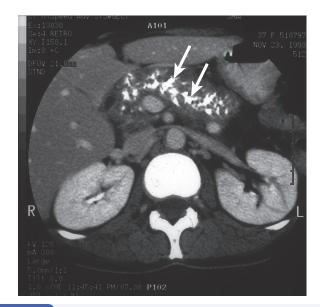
A computed tomography scan demonstrating diffuse pancreatic calcification in a patient with long-standing chronic pancreatitis (arrows).
